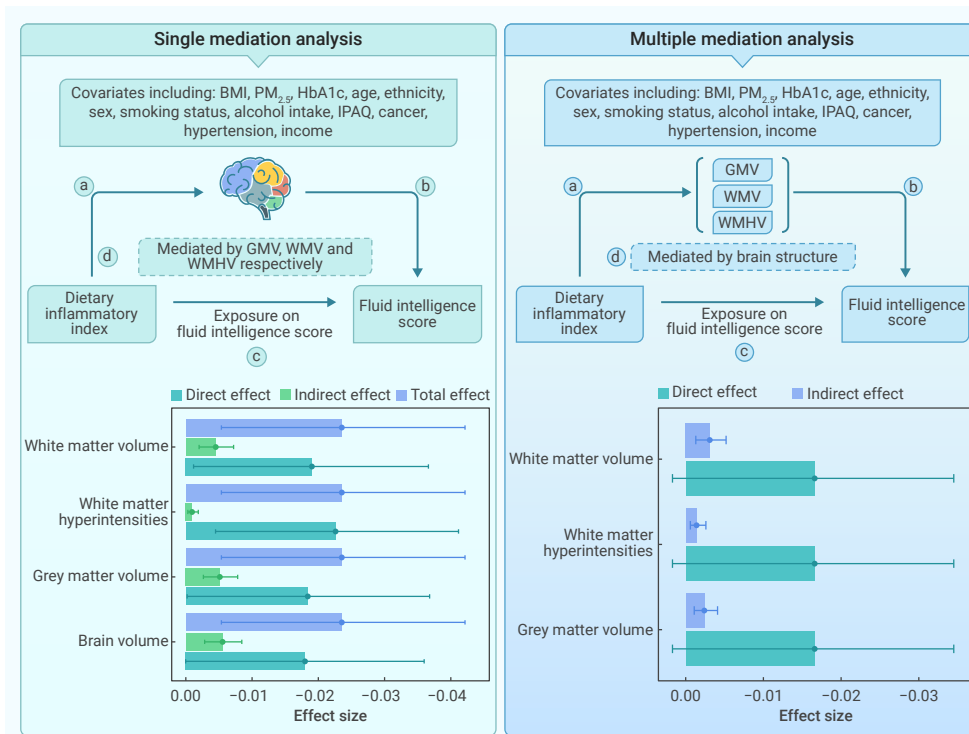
Brain MRI metrics partly mediate the association between DII and fluid intelligence score.
